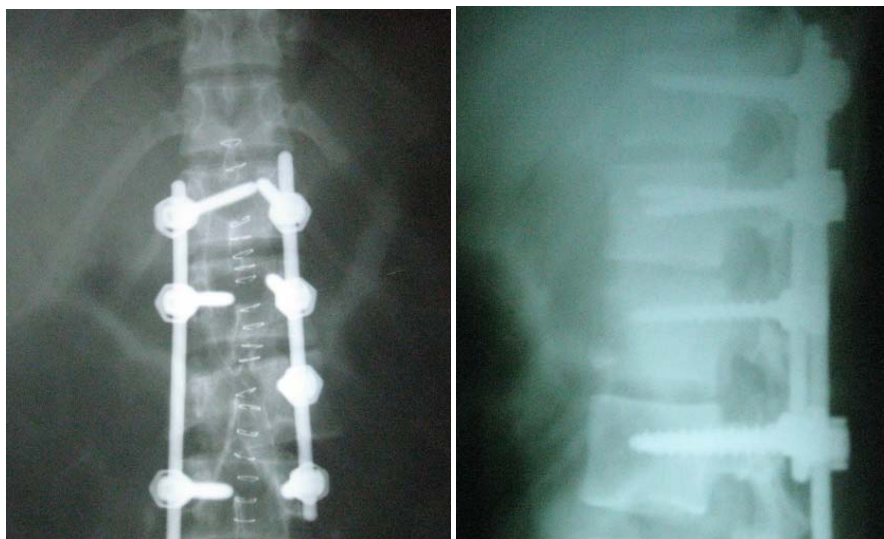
12 month's postoperative xray showing maintainance of kyphotic correction and vertebral body height.
